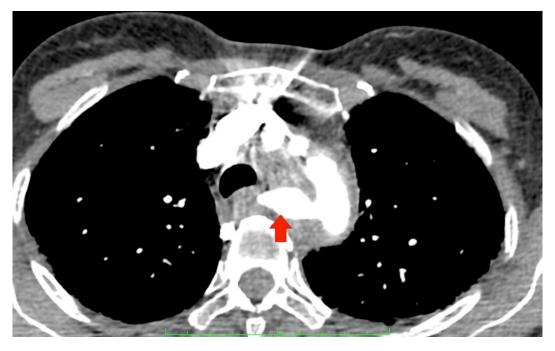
Pseudoaneurysm of the thoracic aorta adjacent to the esophagus, shown on chest computed tomography scans
